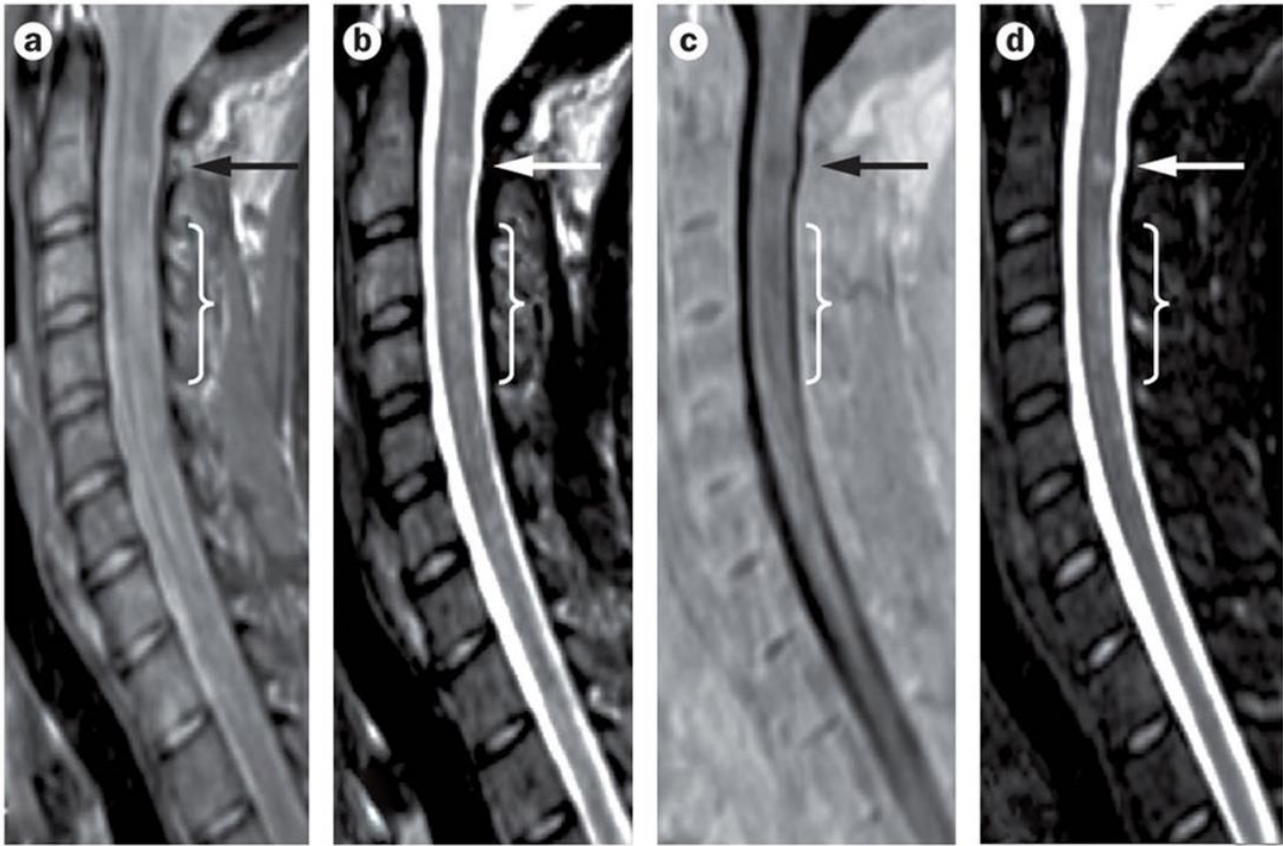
Multiple sclerosis SC lesions in sagittal images acquired with: a) Proton-density-weighted, b) T2-weighted, c) phase-sensitive inversion recovery and d) short tau inversion recovery imaging ⁵.
